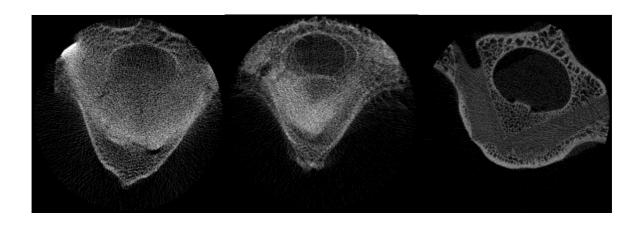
9: Micro CT imaging post injection. Cerament, Competitor and our product
